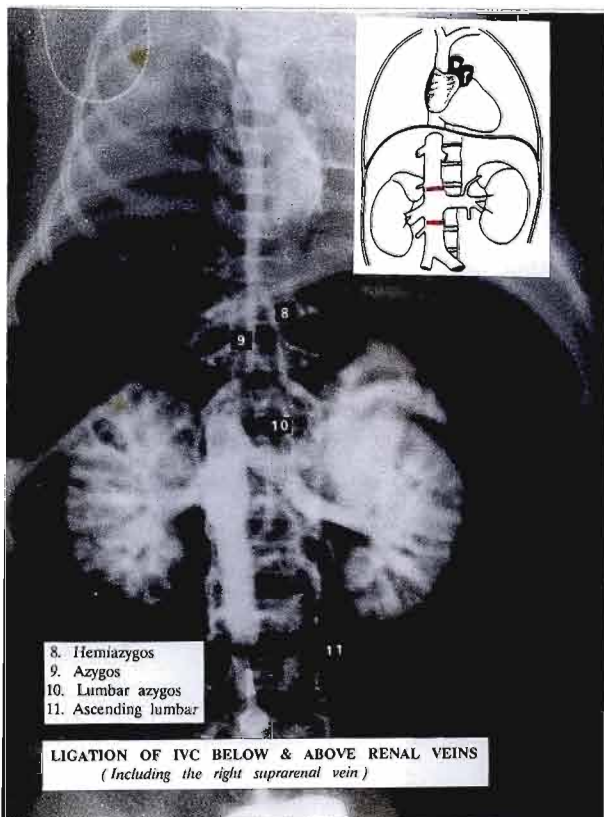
A subsequent radiograph taken after further contrast injection and just prior to bursting pressure. There is cranial filling of the hemiazygos and azygos veins and caudad retrograde filling of the ascending lumbar channels. Despite excessive perfusion pressure, there are still no collaterals relating to the right renal vein.
